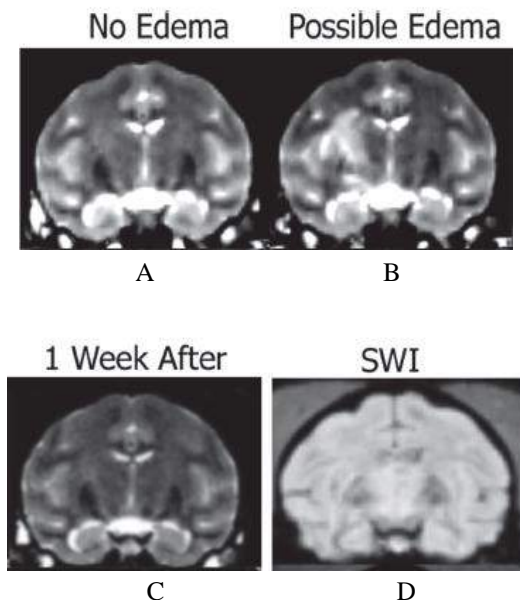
The evaluation of edema using T2-weighted sequences. A. Scan with no edema. B. A scan containing a hyperintense target region with a possible edema. C. No edema, as in A, indicating a reversal from the previous week. D. Scan taken the same day as B, showing the second SWI scan with a possible edema [2].
